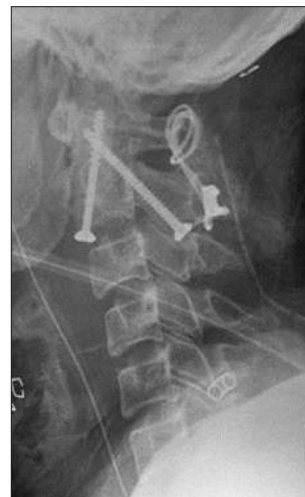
Postoperative lateral cervical radiography revealing anterior transodontoid screw fixation and unilateral C1–2 posterior transarticular screw fixation with wiring achieved reduction of odontoid fracture.
